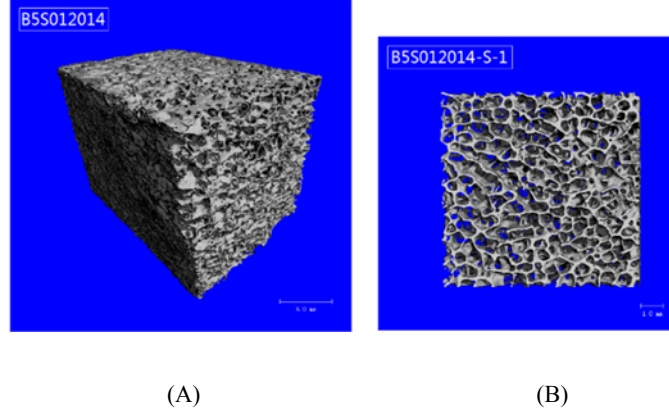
3-dimensional  $\mu$ CT image of a trabecular bone model (A) and a slice cut from center of this model (B). The sample was imaged with nominal resolution of  $15\mu\text{m}$  and had a  $BV/TV=0.18$ . Complex intrinsic structures can be observed.
